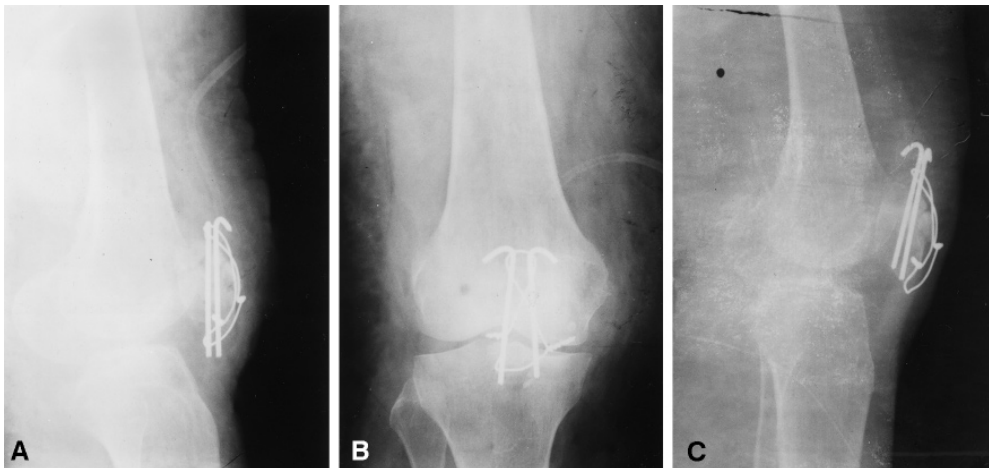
A, B Radiographs after fracture fixation using the AO tension band technique. C After 6 weeks, proximal migration of K-wires has occurred. Compression across the fracture is lost
